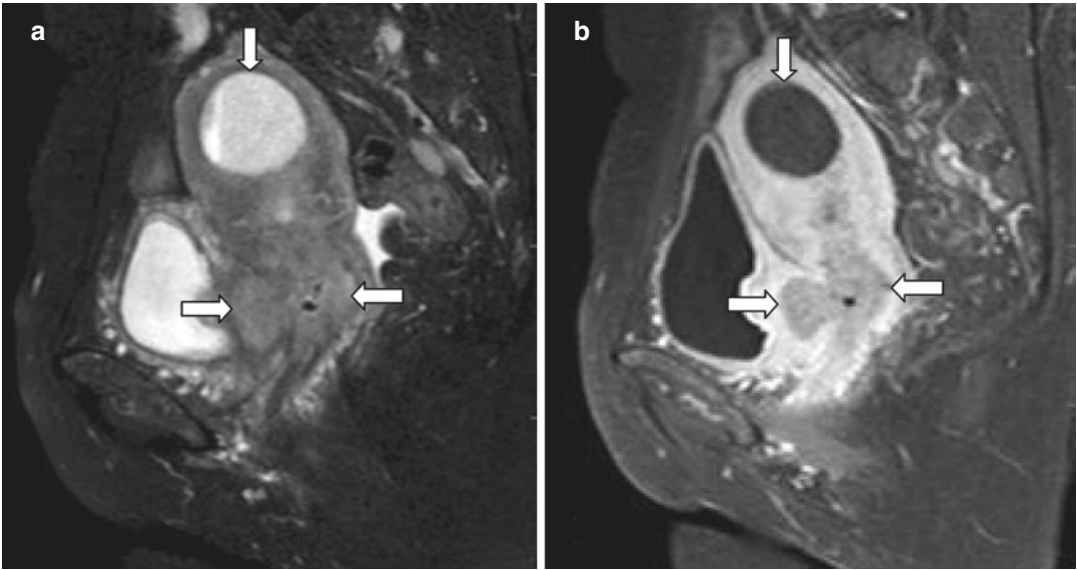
Cervical cancer. (a, b) Sagittal MRI (T2 and T1 contrast) showing a soft tissue mass in the cervix involving both anterior and posterior lip (white horizontal
